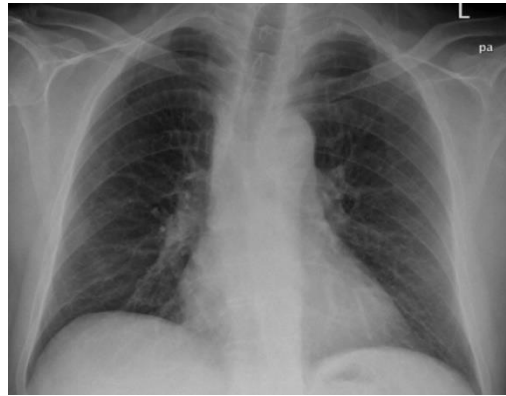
Chest X-ray showing regression of the superior mediastinal mass after treatment with steroid. Reproduced from: [11] under the Creative Commons Attribution License.
